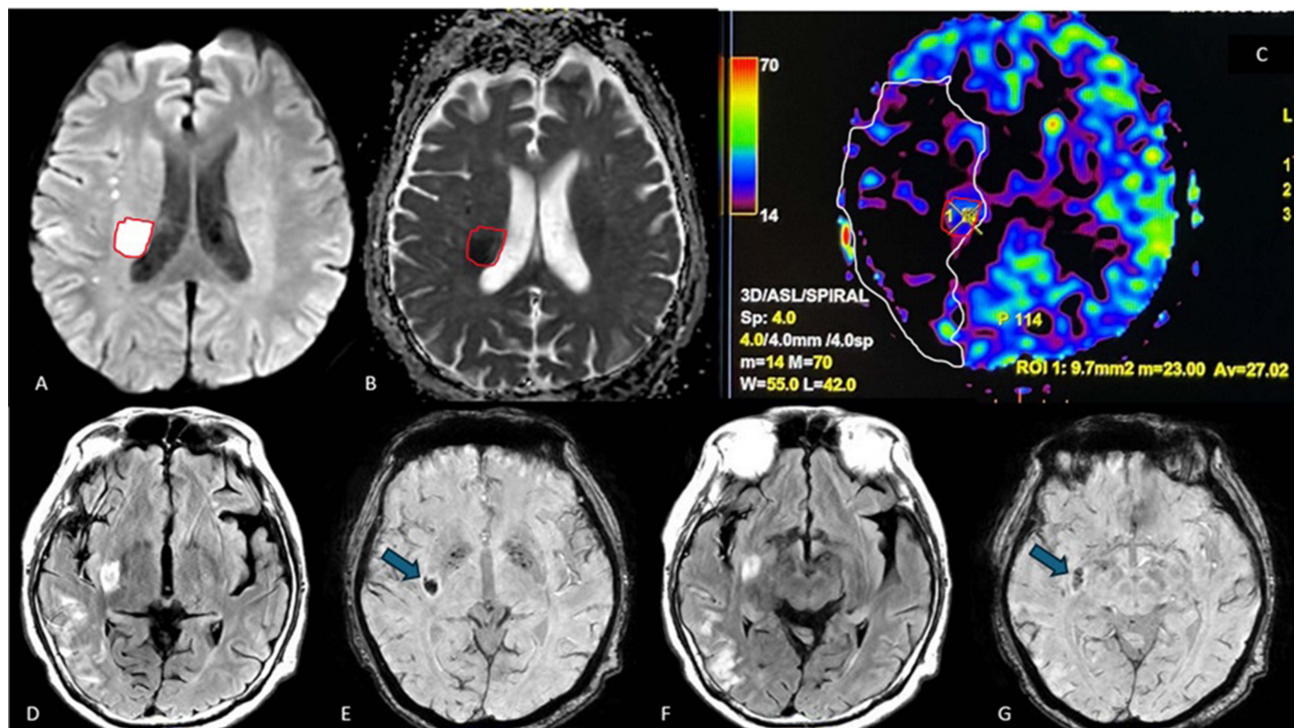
MRI imaging findings in a 73-year-old male presenting with left hemiparesis. MRI revealed multiple infarcts of the Corona radiata visible in DWI (A) and ADC (B) marked by red outline. On ASL MR-perfusion, extensive hypoperfusion can be seen in the right middle cerebral artery (MCA) territory marked by white outline which was not visible in DWI (perfusion-diffusion mismatch), suggesting a large area of penumbra (C). There were also infarcts at the right external capsule, occipital lobe, and the lentiform nucleus visible in FLAIR (D and F), with an appearance of blooming artefact on SWI (arrow), confirming presence of micro bleeding that may progress to hemorrhagic transformation (E and G).
